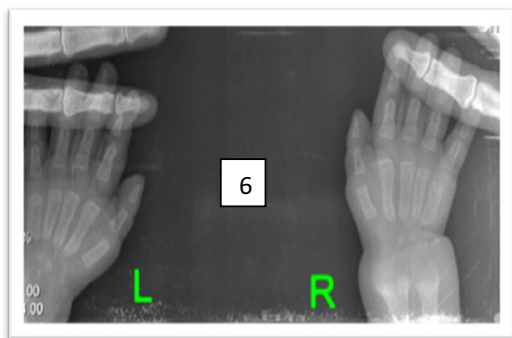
Right and left wrist X-rays of the proband: showed decreased bone mineralization with cupping and fraying over the distal ulnar and radial metaphysis of both bones
